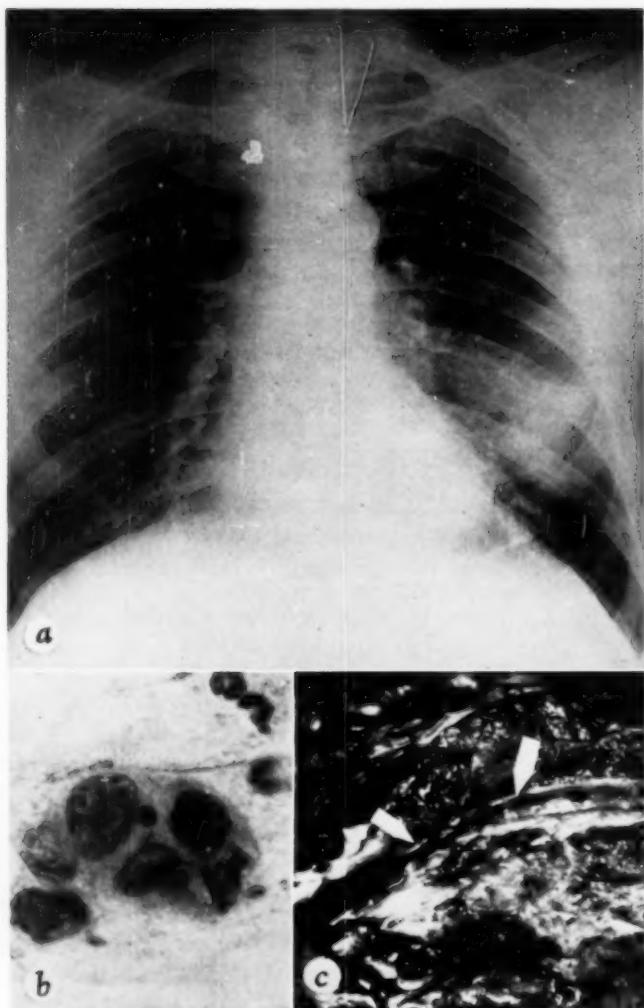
Bronchogenic carcinoma of the lingular division of the upper lobe bronchus. (a) Roentgenographic appearance. (b) Carcinoma cells found in sputum. (c) Gross lesion. The segment of bronchus involved measured 1.2 cm. in length. There was infiltration of the carcinoma through the entire thickness of the bronchial wall but not into the surrounding lung.
